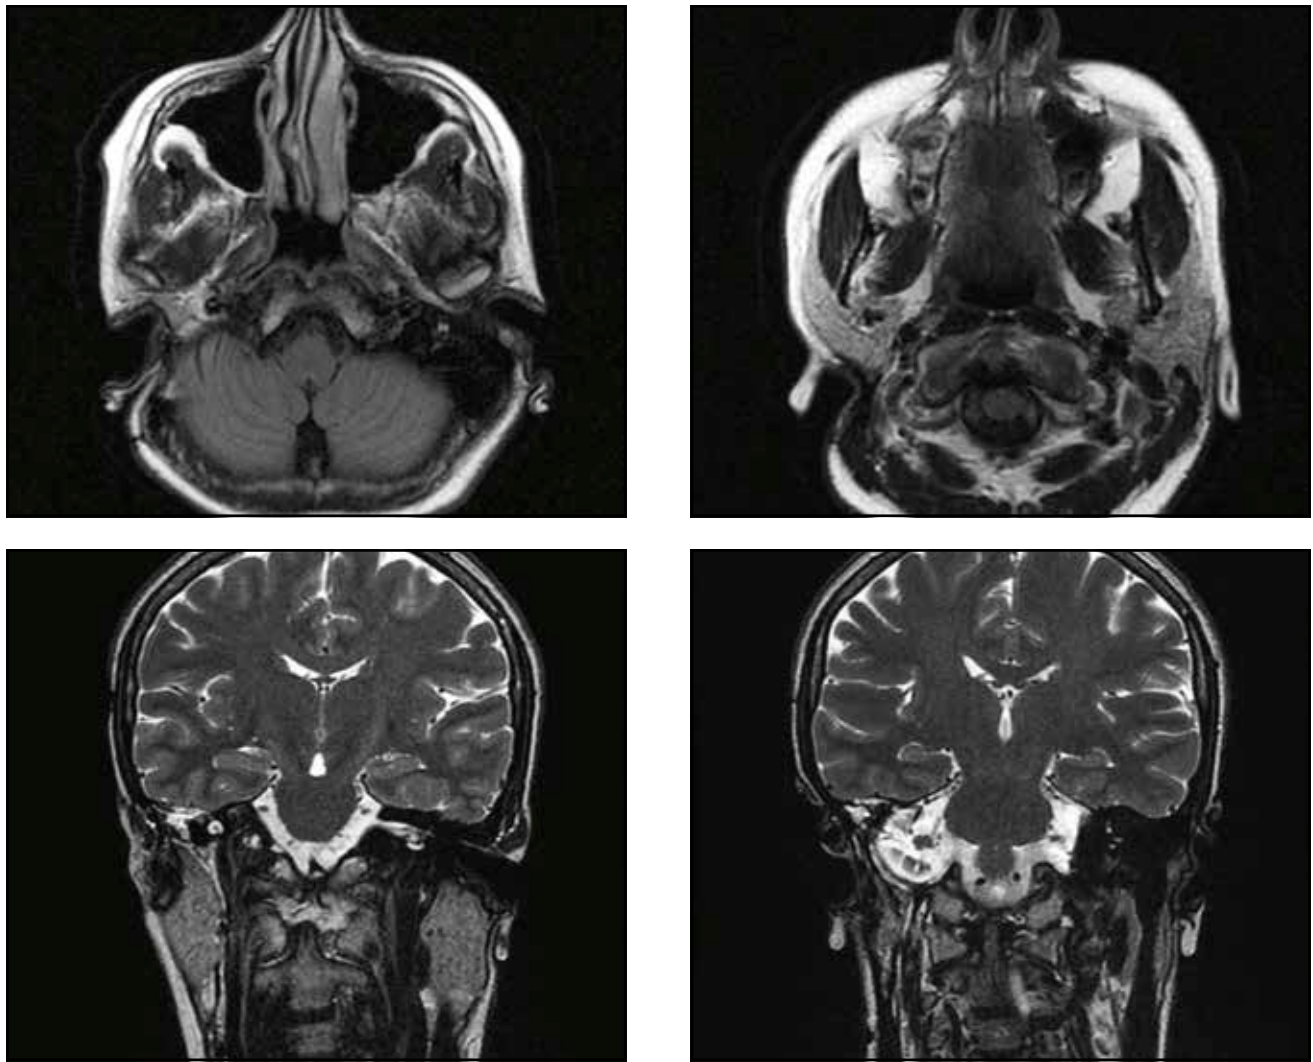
Head and neck MRI, 2 months postoperatively, axial and coronal slices – autologous adipose graft in the temporal bone, without intense contrast setting at this level; slight dural, linear contrast, at the ponto-cerebellar angle, possibly postoperatively, without any signs of recurrence.
